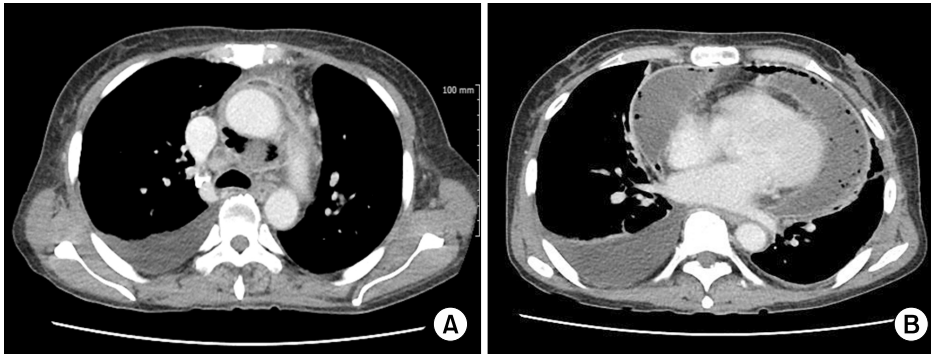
(A, B) Preoperative computed tomography images show a large pericardial effusion contained with air bubbles and an intact ascending aorta. This image was taken at another facility just before transfer to Dankook University Hospital.
